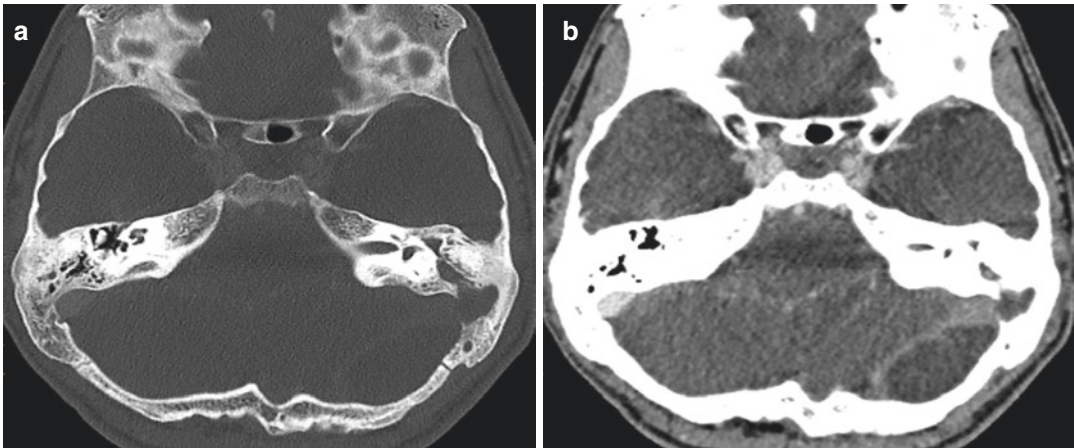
Epidural empyema. (a) CT scan (bone window): presence of abnormal soft tissue attenuation in the left right mastoid air cells (acute mastoiditis) with erosion of the sigmoid plate. (b) CT scan after contrast medium
